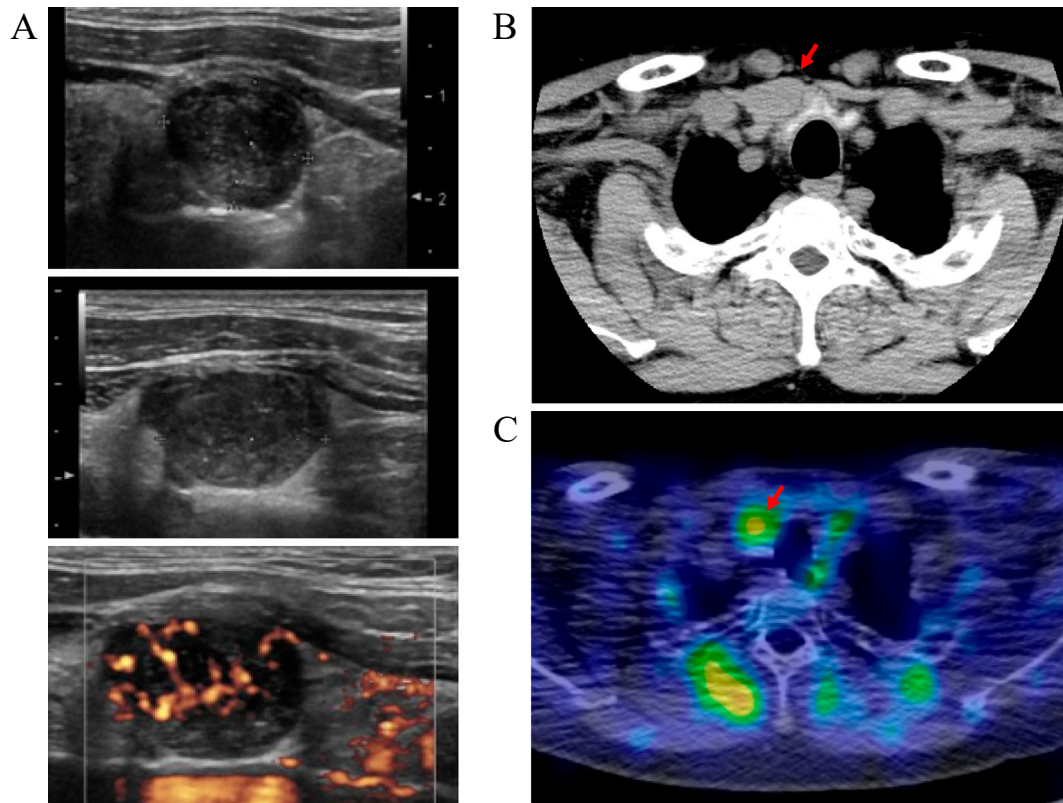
A: Neck ultrasonography on the first visit showing an approximately 20-mm hypoechoic nodule inferior to the right lobe of the thyroid gland, with internal heterogeneity and abundant blood flow. The nodule in the right lung had shrunk (red arrow), B: CT scan showing a tumor in the same area as on ultrasonography. C: ^{99m}Tc -sestamibiscintigraphy SPECT/CT fusion imaging showing a mild uptake of the radiotracer in the same area. SPECT/CT: single-photon emission computed tomography/computed tomography, CT: computed tomography
